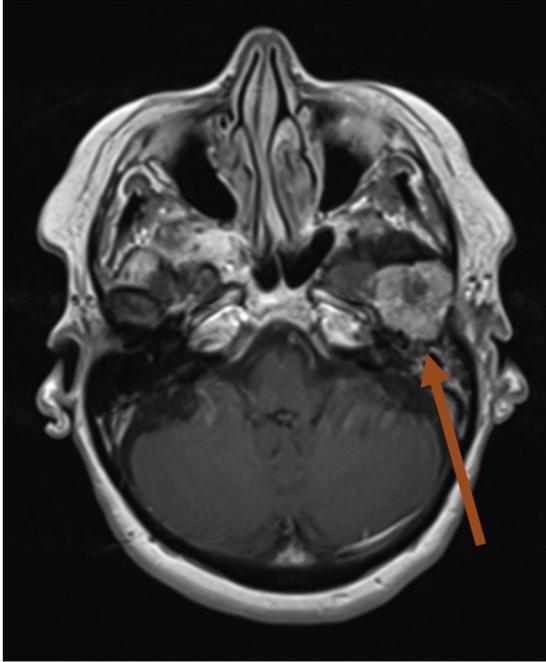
Axial view of T1-weighted magnetic resonance image with tumour in the left temporomandibular joint (arrow).
